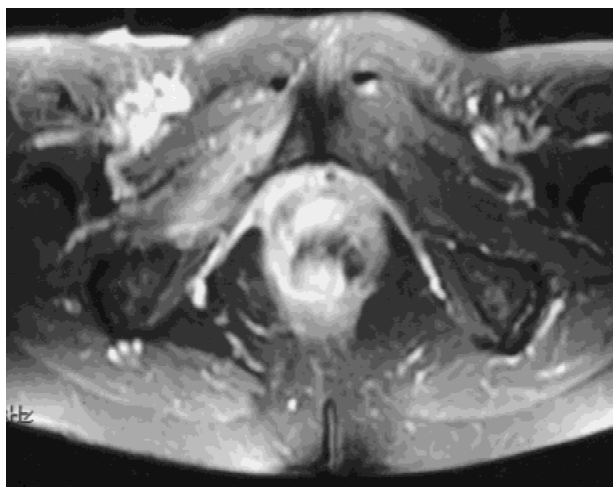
Pelvic magnetic resonance imaging demonstrating increased signal within the right obturator canal consistent with metastatic transitional cell cancer of the bladder.
